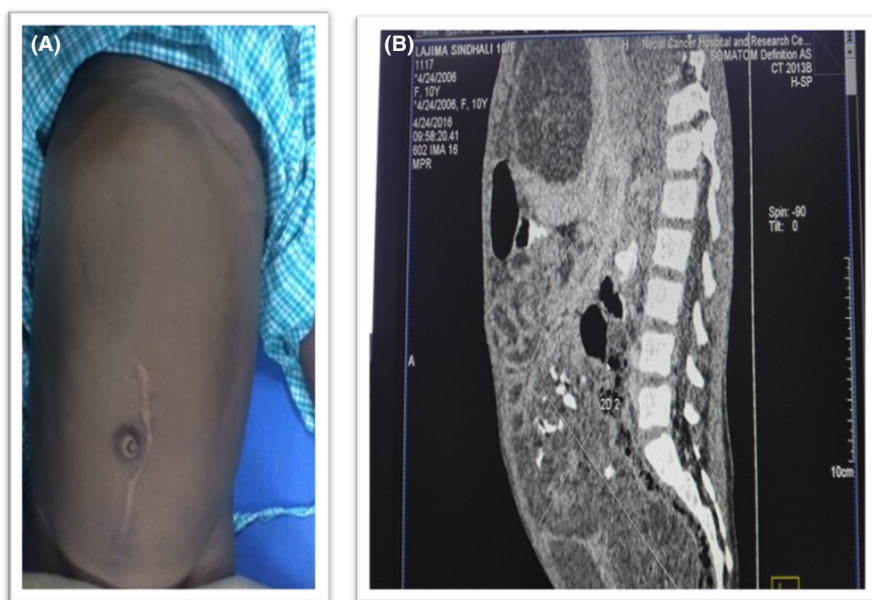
(A) Clinical photograph of abdomen showing huge abdominopelvic mass; (B) CT Scan shows multiple intraperitoneal masses
